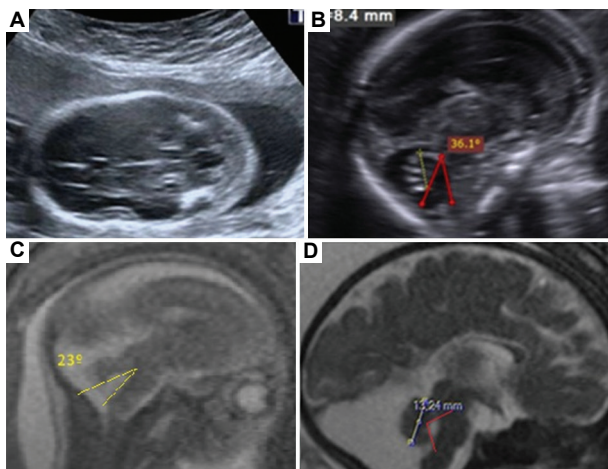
Ultrasound and MRI images of different patients. (A and B) Axial and sagittal ultrasound images show a slightly enlarged fourth ventricle, minimal upward rotation of the hypoplastic vermis, and an increased tegmentovermian angle. (C) A sagittal HASTE image of a 21-week fetus shows an increased tegmentovermian angle associated with vermian hypoplasia. (D) Sagittal TRUFI images of a 34-week fetus demonstrate a small vermis consistent with gestational age and an acute fastigial recess (thin line angle).
